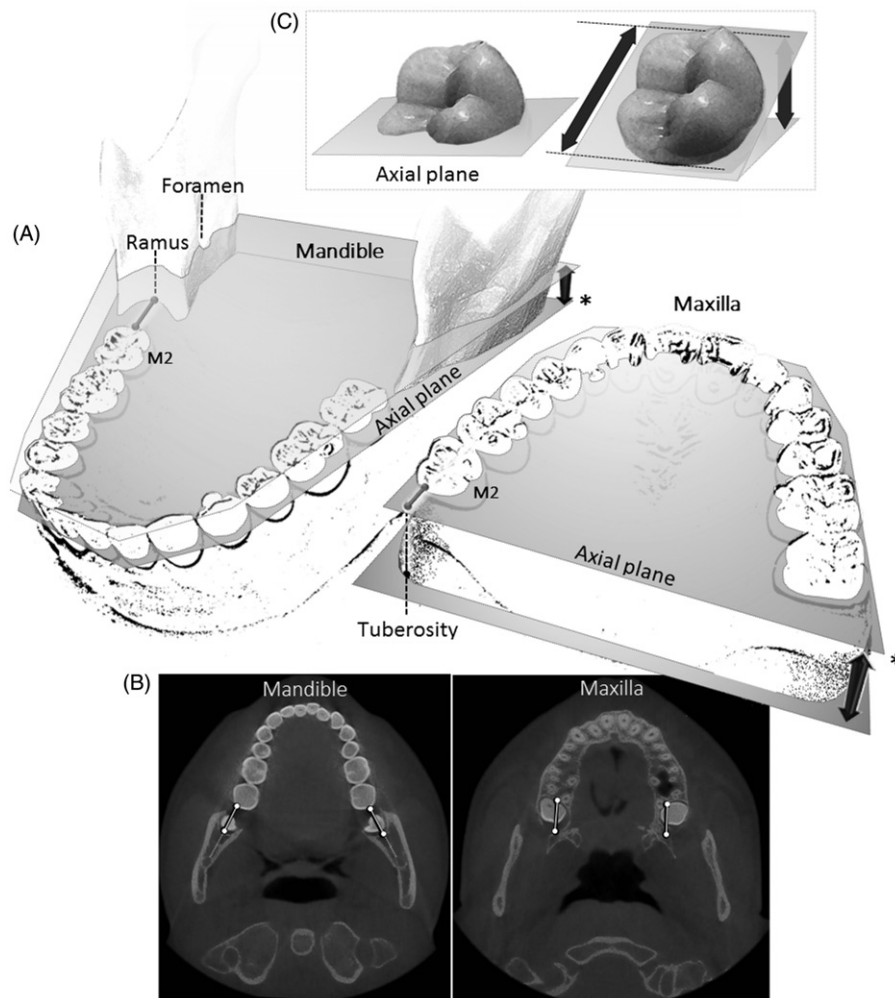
Measurement design using CBCT imaging. (A) Measurements were taken on the axial view, with the axial plane positioned parallel to the occlusal plane and at the level of the interproximal contact points of the permanent molars and premolars⁽⁹⁾. From that level, the axial plane can be moved upwards or downwards in order to allow the distance between structures that are located in distinct levels to be linearly measured. The space M2-ramus was measured from the distal-most point of the M2 crown to the ascending ramus of the mandible, at the level where the axial plane touches the ascending mandibular ramus. This measurement was taken parallel and adjacent to a straight line created from the M2 to the mandibular foramen. In the maxilla, the space M2-tuberosity was calculated by linearly measuring the distance between the distal-most point of the M2 crown to the distal-most point of the maxillary tuberosity. (B) CBCT images of the maxilla and mandible showcasing the measurement procedure. (C) The mesiodistal diameter of the M3 crown was also measured. Because M3s are very often inclined (left image), a compensatory inclination of the axial plane allowed their maximum mesiodistal crown diameter to be measured with greater accuracy (right image).
